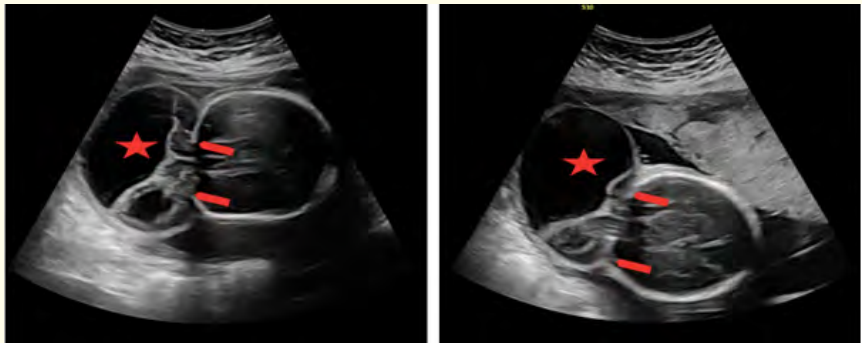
Two axial fetal ultrasound sections showing a midline occipital, mainly cystic extracranial mass (asterisk) with an echogenic solid component continuous with intracranial brain through an occipital calvarial defect (arrows), diagnostic of an occipital encephalocele.
